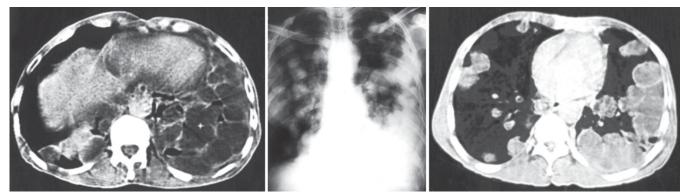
Radiography in a patient with multiple hydatid cysts
